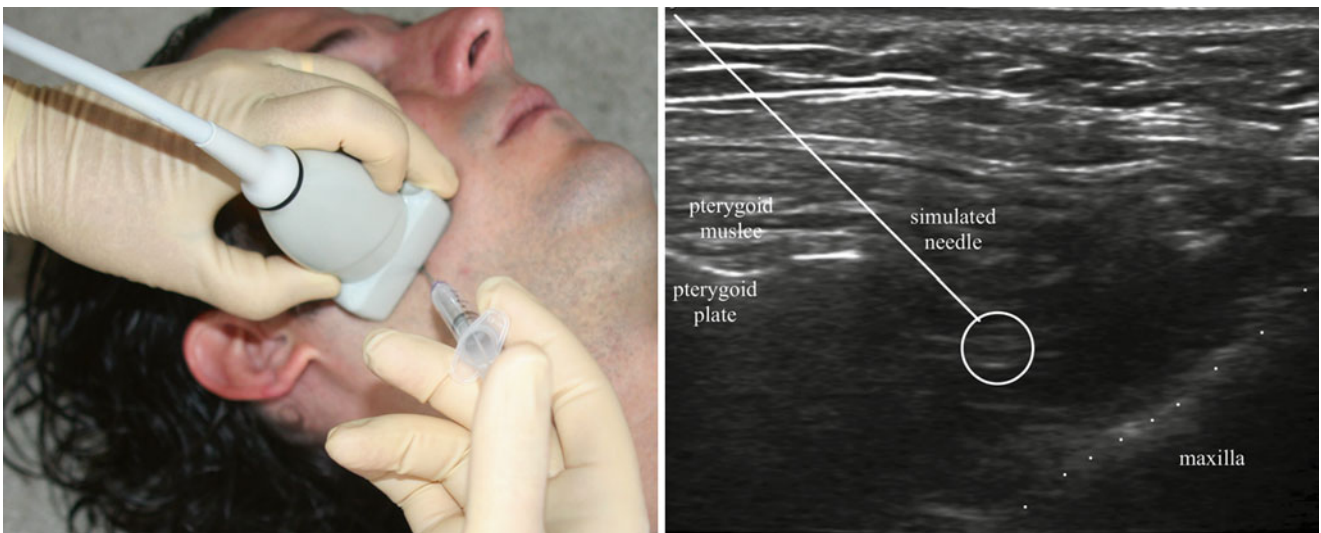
Ultrasound-directed injection of the maxillary nerve (Image courtesy of Andrea Trescot, MD)
